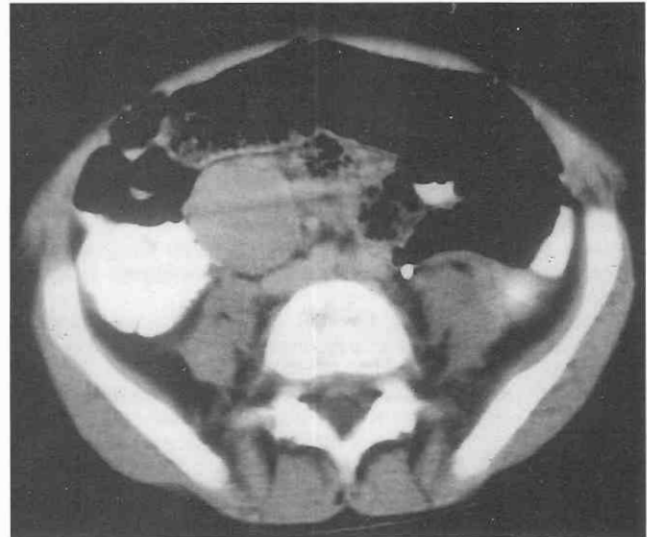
Castleman's disease of the mesentery. CT scan through the lower abdomen demonstrates a large, solid mass in the mesentery. At surgery, this was noted to be Castleman's disease.
